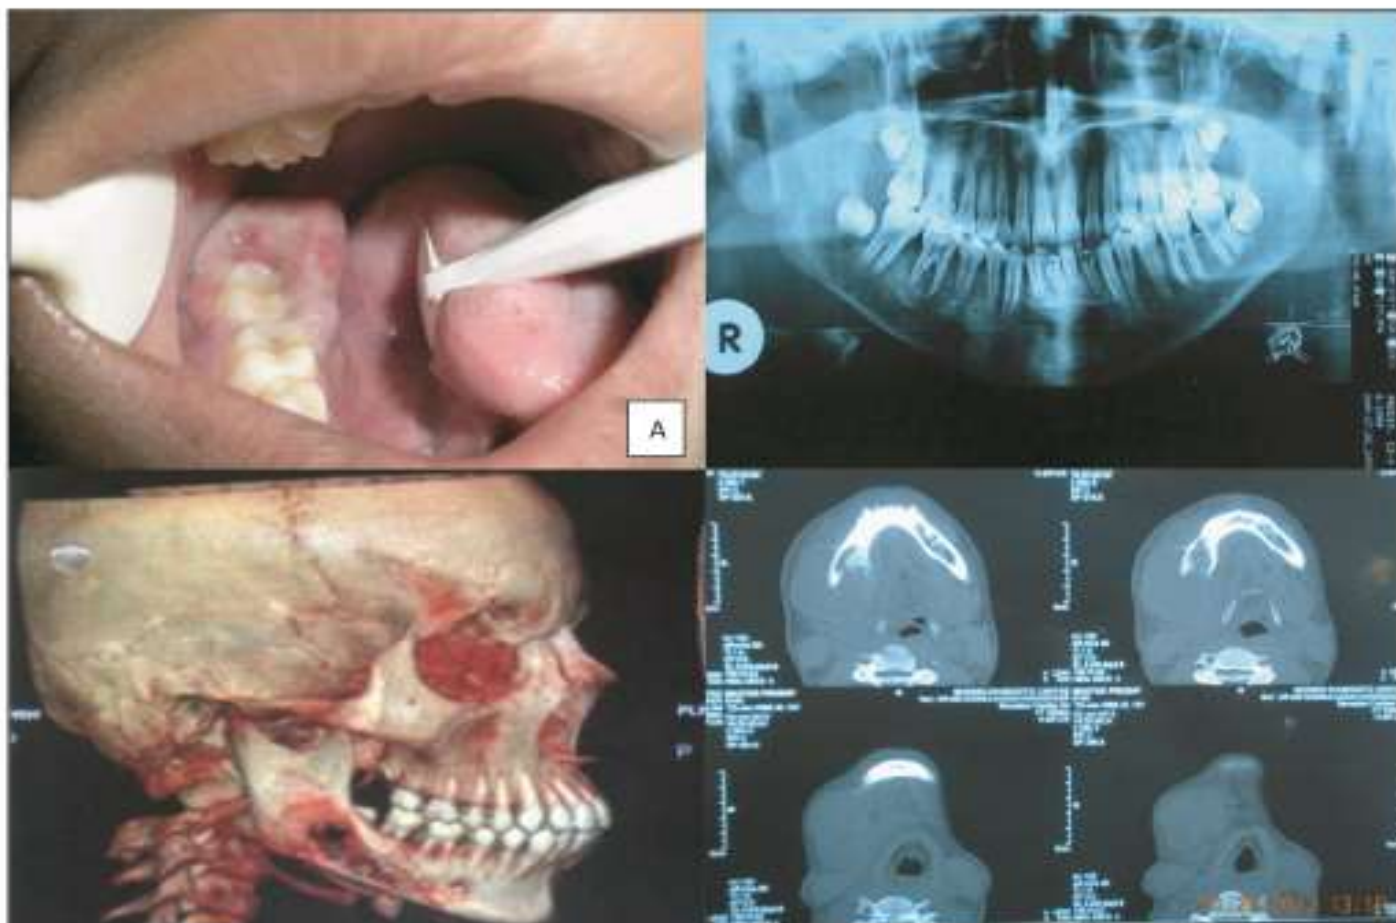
Showing Clinical, OPG & CT Scan view of MFH.
